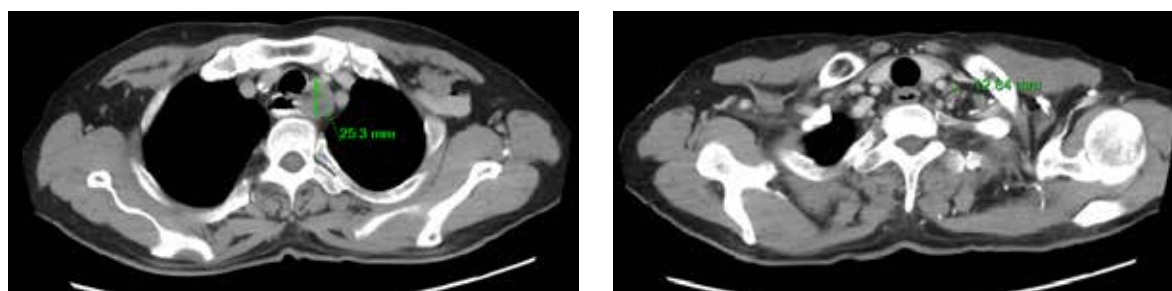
Chest computed tomography (CT) scan at the time of diagnosis on January 13, 2024
